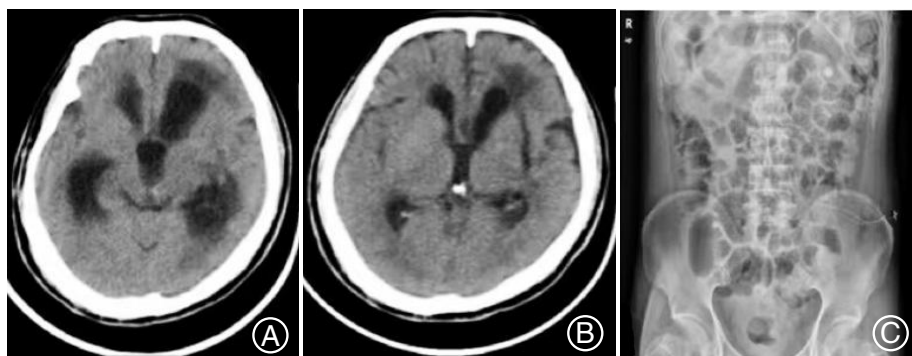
典型病例, A 为术前 CT, B 为术后 17 d CT, C 为术后腹部 X 线平片
